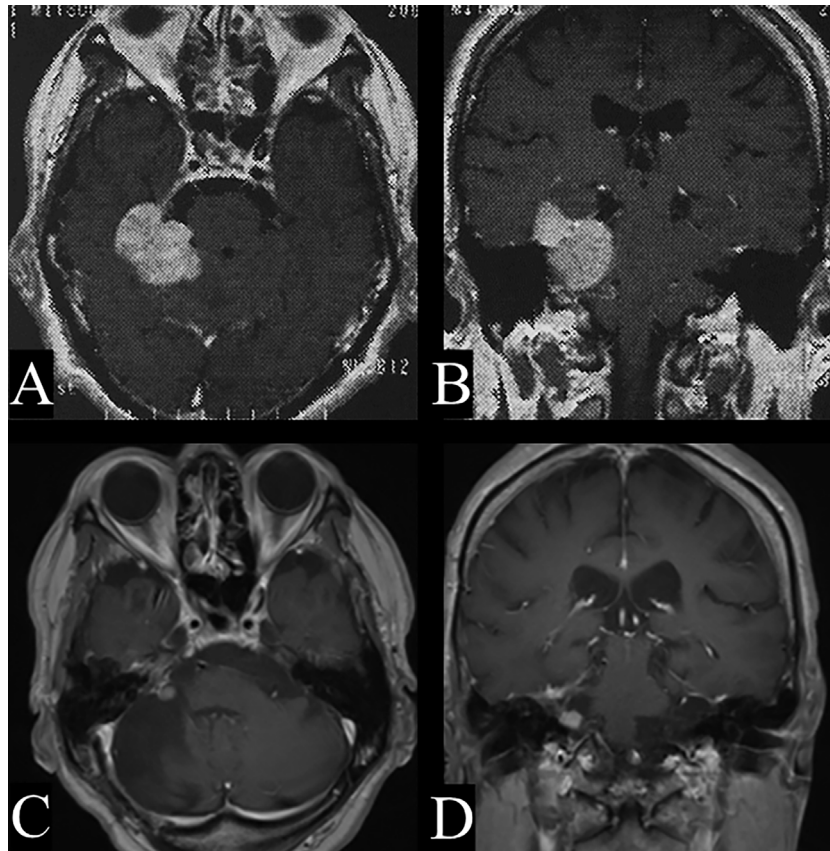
(A, B) Initial magnetic resonance imaging (MRI) showing right tentorial meningioma. (C, D) MRI 16 years after the initial surgery showing residual tumor in the posterior fossa.
